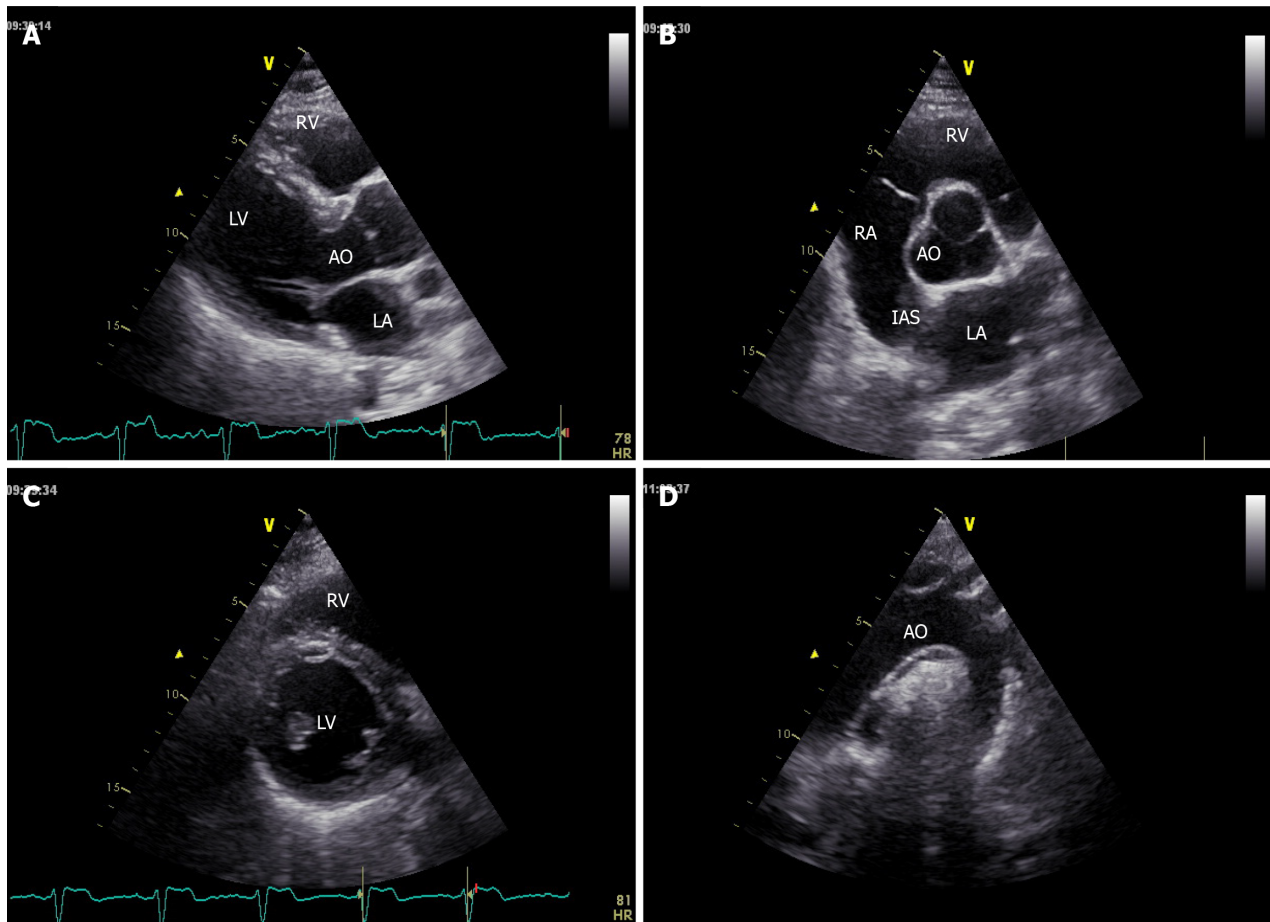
Parasternal long-axis, short axis and suprasternal windows showing left and right chambers and aortic valve and arch. A: Long-axis; B and C: Short axis; D: Suprasternal windows. LV: Left ventricle; LA: Left atrium; RV: Right ventricle; RA: Right atrium; AO: Aorta; IAS: Interatrial septum.
